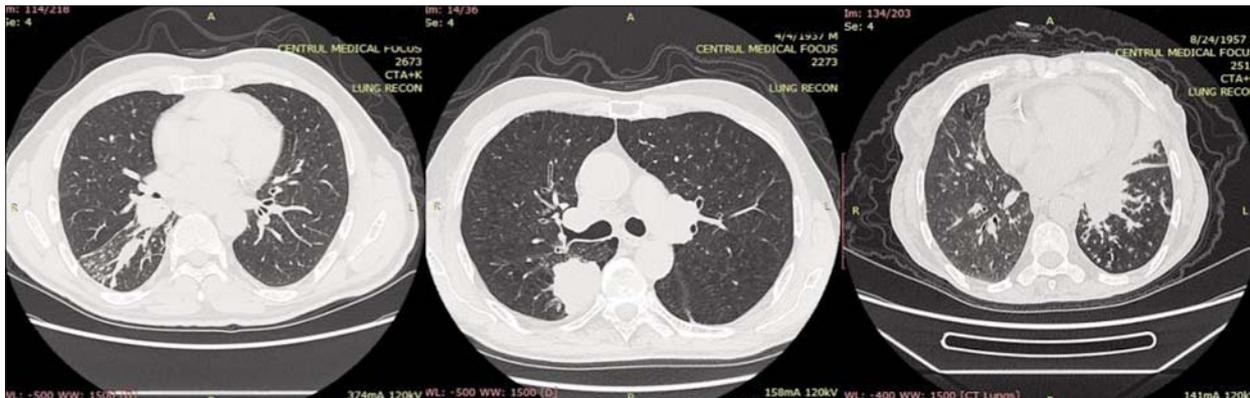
Computed tomography: aspects of lung tumors
